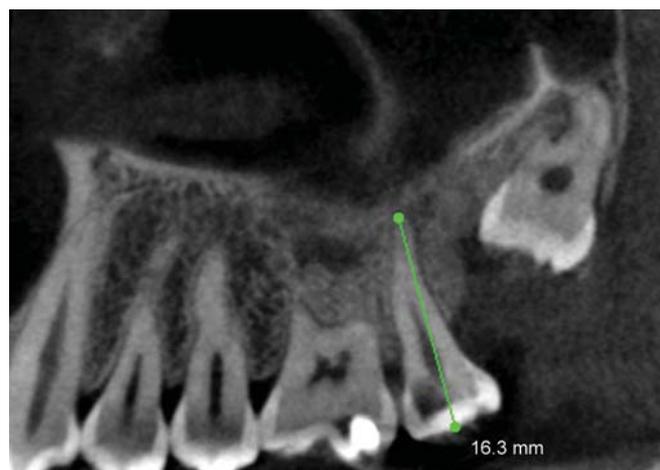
CBCT image (approximate canal length of buccal canal)
